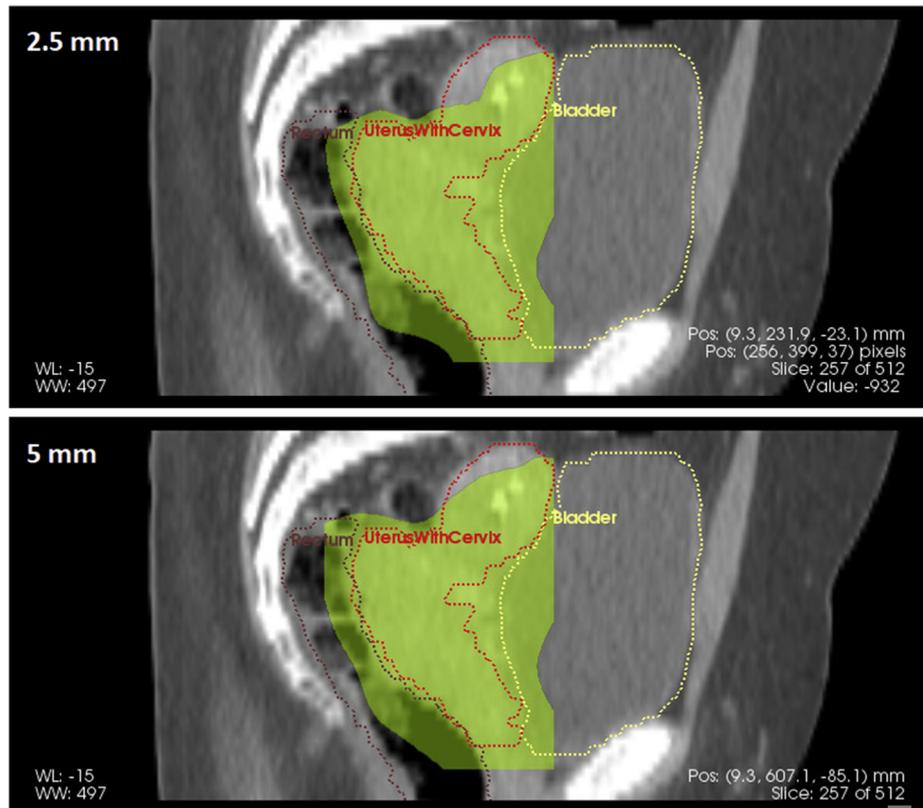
Accumulated V42.75 Gy (colored regions) from the 4 beams of 1 fraction on sagittal view of the planning computed tomography (CT) with 2.5 mm (top) and 5 mm (bottom) margins. The red contour is the primary clinical target volume (pCTV) and the yellow one the bladder. (A color version of this figure is available at <https://doi.org/10.1016/j.ijrobp.2020.11.037>.)
